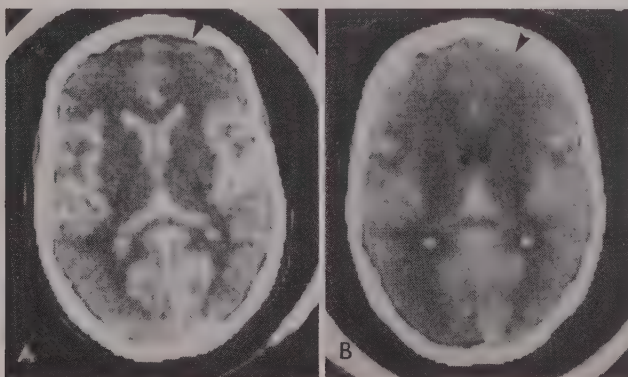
Metrizamide CT Cisternography. Normal Dynamics. A, CT at zero hours, after intrathecal instillation of metrizamide. Ventricular reflux fills the lateral ventricles, Sylvian fissure and adjacent sulci symmetrically. The ventricles are not enlarged. There is no periventricular edema or parenchymal brain blush. B, CT 8 hours later reveals marked clearing of metrizamide from the ventricles and beginning parenchymal brain blush (arrowhead). (Compare the density of the frontal and occipital lobes with that in A. Images exposed at identical settings).
